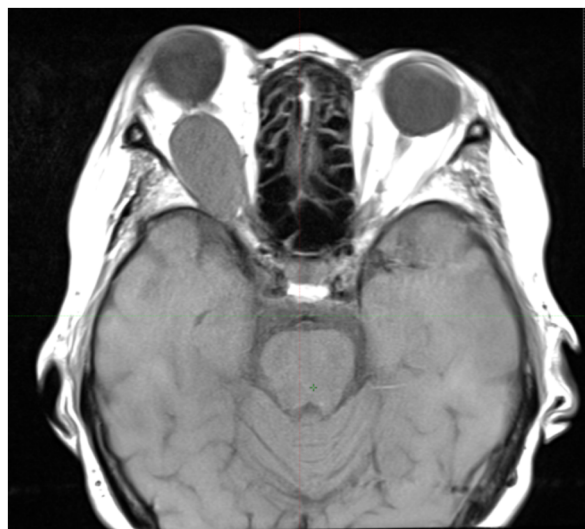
Magnetic resonance imaging before surgery
